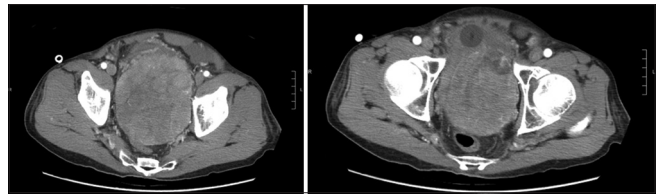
Contrast CT showing 12 cm left SV metastasis posterior to bladder. CT: Computed tomography, SV: Seminal vesicle
